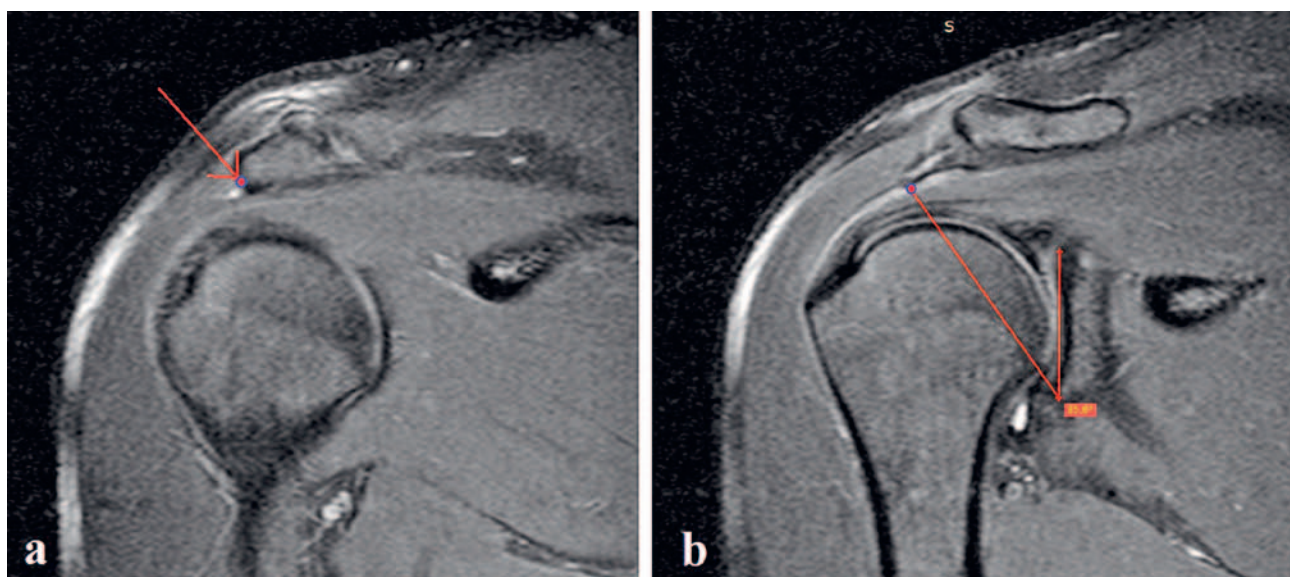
Measurement of the critical shoulder angle on coronal magnetic resonance image.
